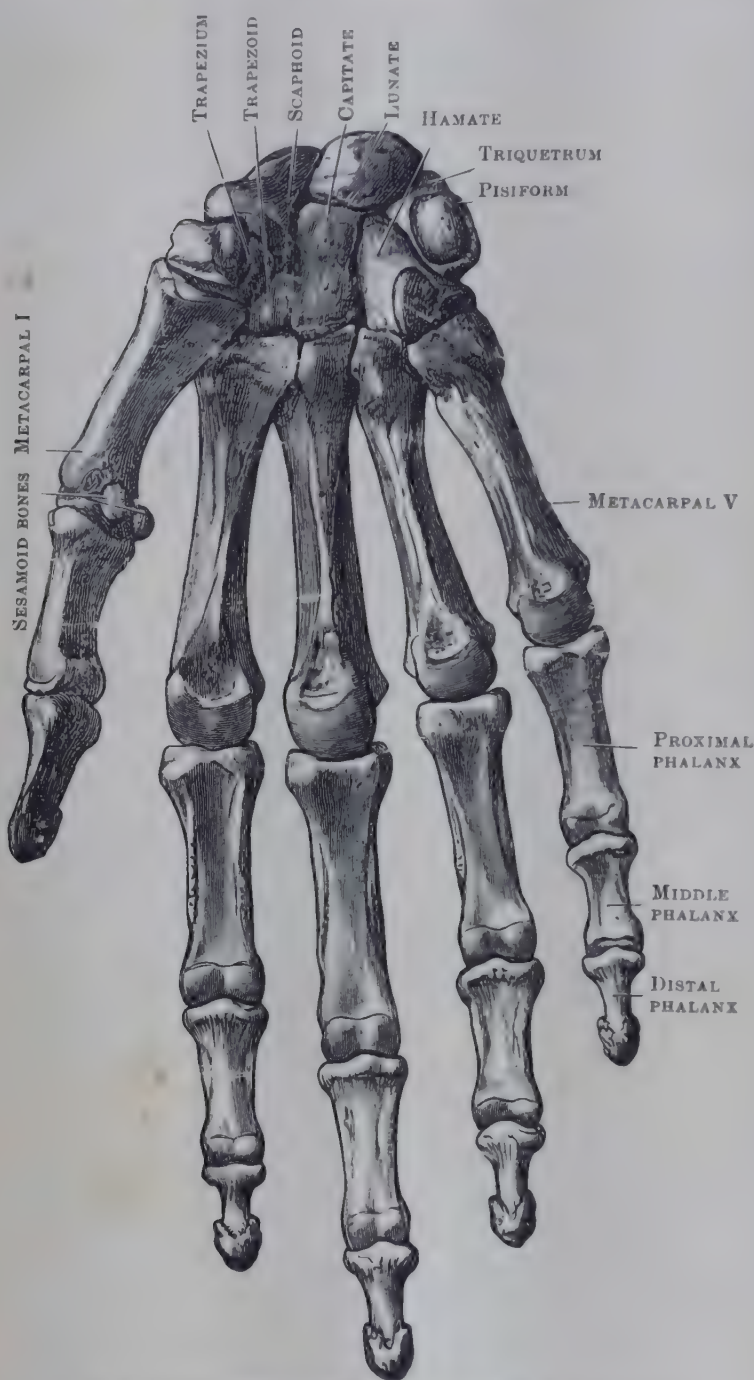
PALMAR ASPECT OF BONES OF RIGHT HAND.
